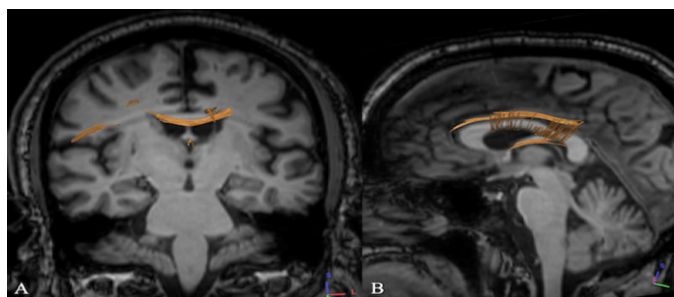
Differential tractography reveals significant changes in white matter microstructure in the left fornix, corpus callosum, left cingulum, right centrum semiovale and perisylvian white matter. Results comparing baseline and 3 months post-FUSA diffusion MRI on coronal (A) and sagittal (B) projections.
